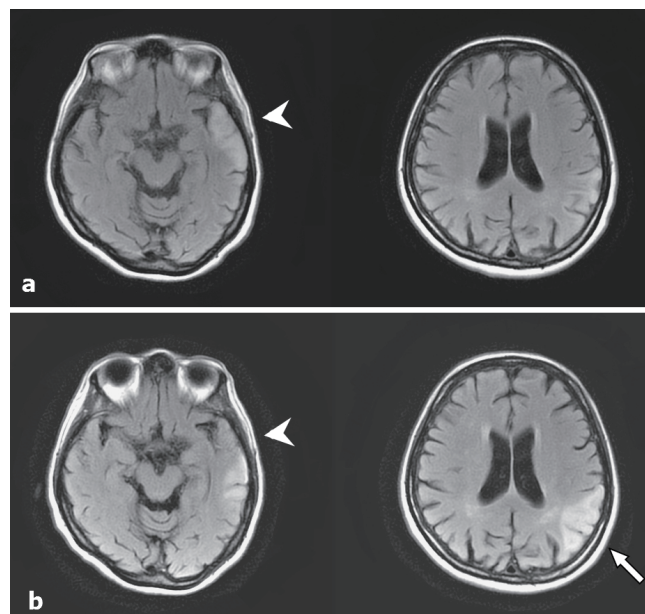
The follow-up MRI one month after (a) the first study (b), which shows spatial migration from the left temporal lobe to the parietal lobe. Partial regression of the lesion at the temporal pole (arrow head) with extension to the parietal lobe (long arrow) was seen. This unique interval feature is characterized in MELAS syndrome.
